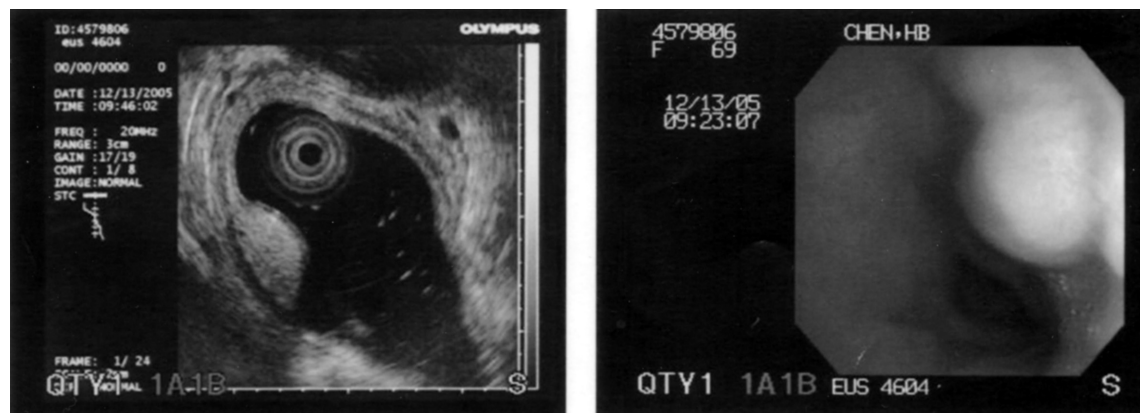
Endoscopic ultrasonography revealing a 1.0 cm polypoid hyperechoic tumor arising from the third layer of the esophageal wall, with intact mucosa at 27 cm below the incisors in the middle esophagus.
